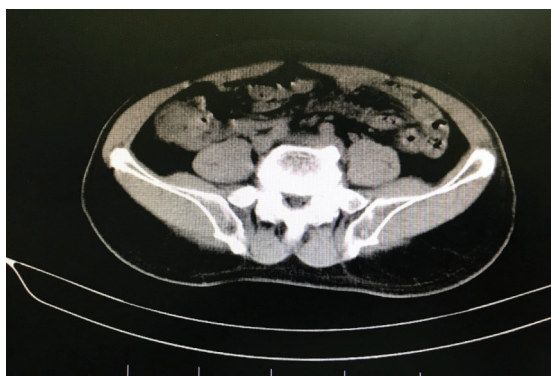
Normal abdominal wall revealed by CT-scan.
